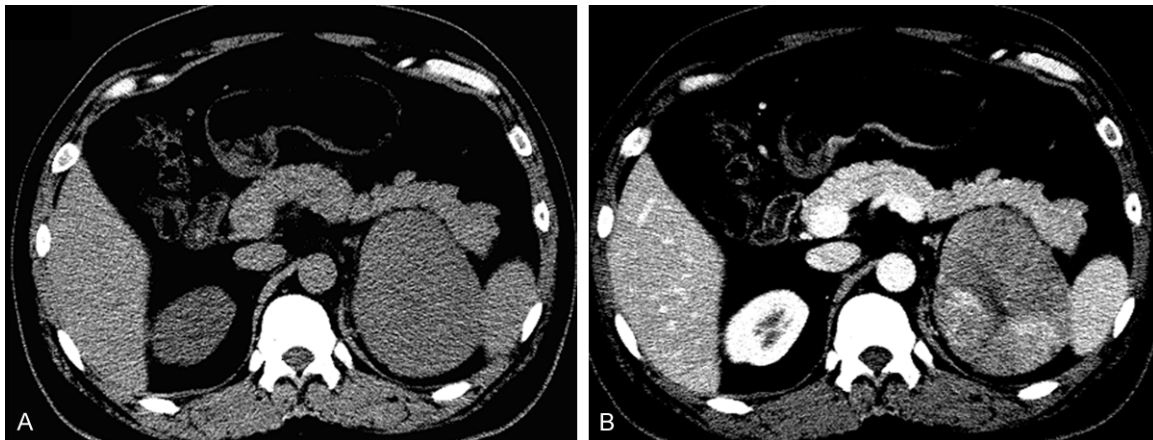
A 30-year-old male with cortical carcinoma of the left adrenal gland. A. The mass shows well-circumscribed, ovoid shape and homogeneous attenuation on non-enhanced CT. B. The mass presents moderately heterogeneous enhancement after contrast administration.
